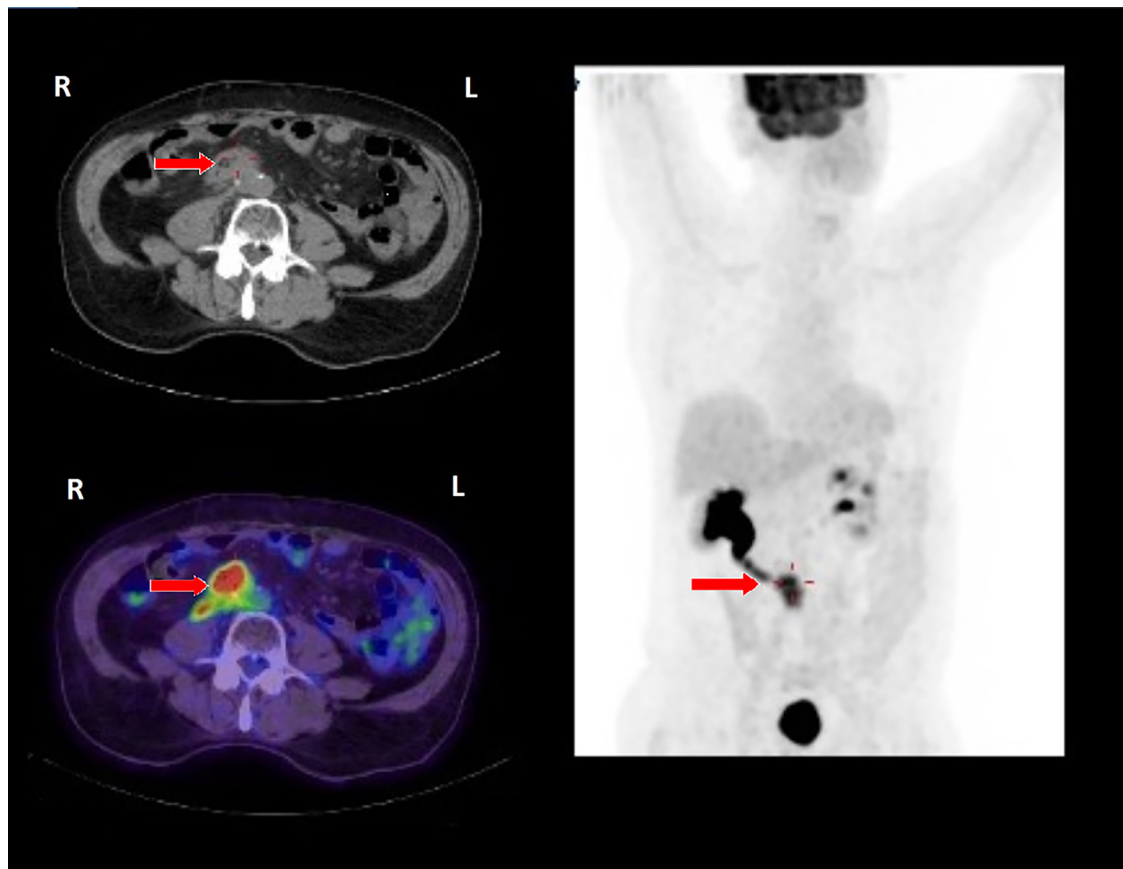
Selected PET-CT images showing the metastatic right sided para-aortic lymphadenopathy that was targeted by external beam irradiation. This is involving the right ureter with resulting right sided hydronephrosis, as seen in the coronal PET image.
